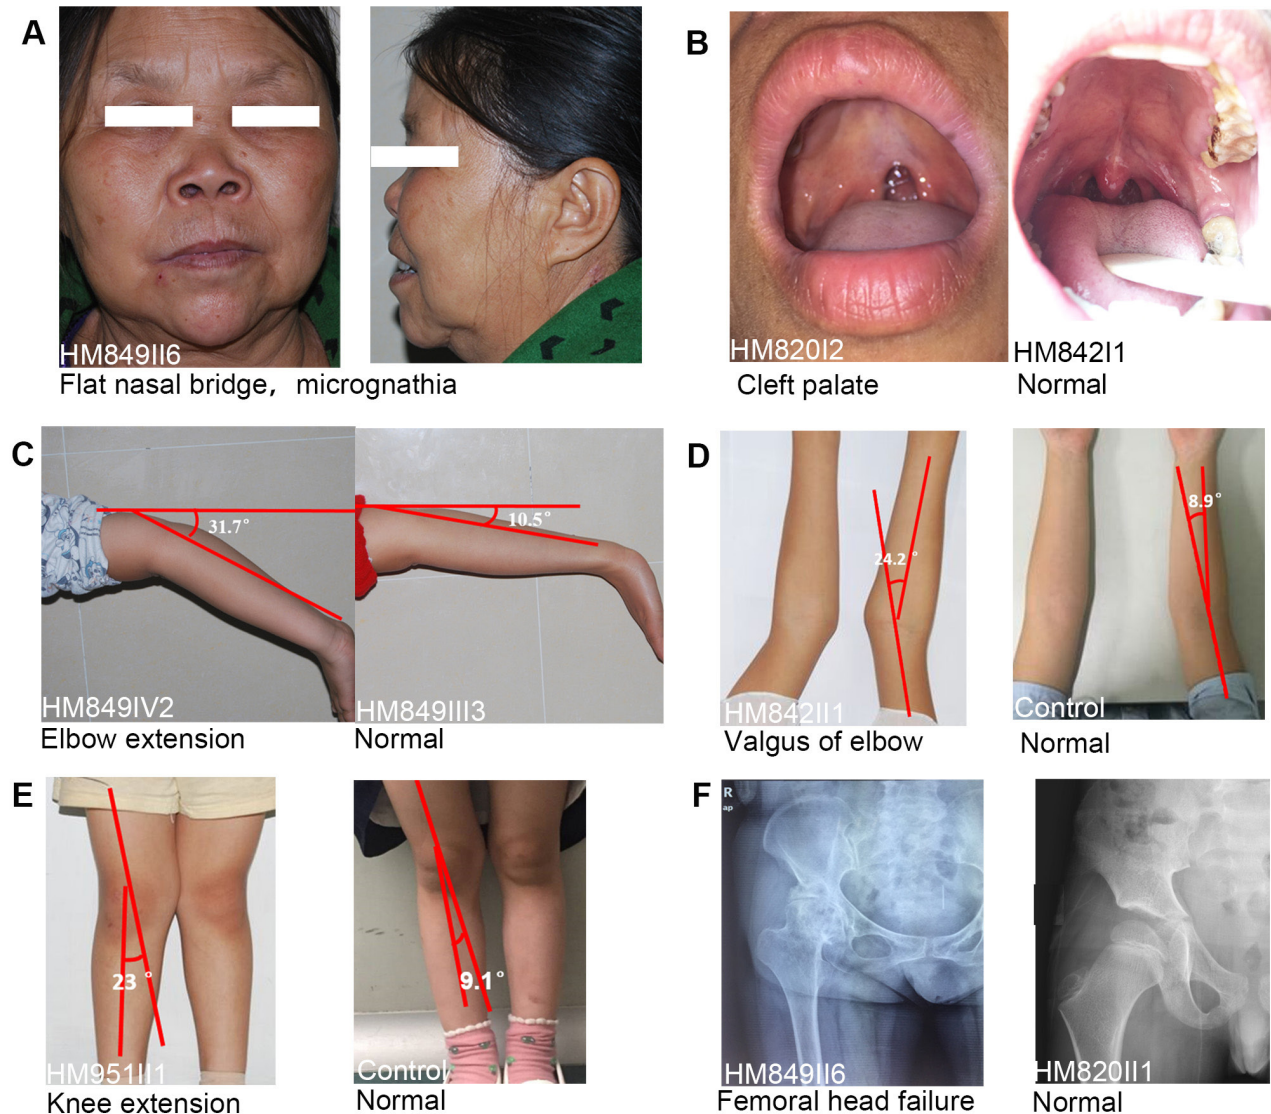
Systemic manifestations of patients with mutations in *COL2A1* or *COL11A1*. A: Frontal and profile facial images of HM849II6. A flat midface with a depressed nasal bridge, a short nose, and micrognathia can be seen in HM849II6. B: Oral photographs of HM820I2 and HM842I1. A cleft palate can be seen in HM820I2, while HM842I1 is normal. C: Hypermobility of the elbow. Hyperextension of the elbow joint can be seen in HM849IV2, while HM849III3 is normal. D: Valgus of the elbow. Valgus of the elbow can be detected in HM842I1 with a normal control beside it. E: Valgus of the knee can be seen in HM951I1 with a normal control beside it. F: Hip-joint X-rays of HM849II6 and HM820III1. The X-ray of HM849II6 shows femoral head necrosis, while the hip joint of HM820III1 is normal.
